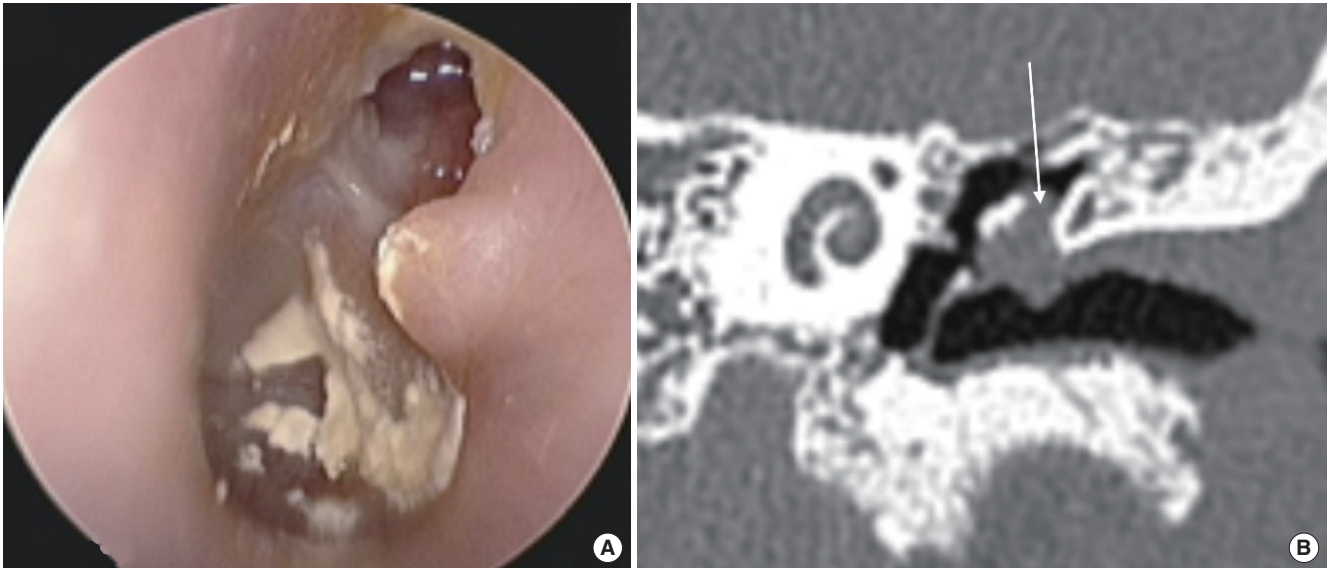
Preoperative findings. (A) Attic destruction was observed on otoscopic examination. (B) Coronal computed tomography scan of the left temporal bone shows erosion of the scutum and soft tissue density (arrow) in the left Prussak's space.
